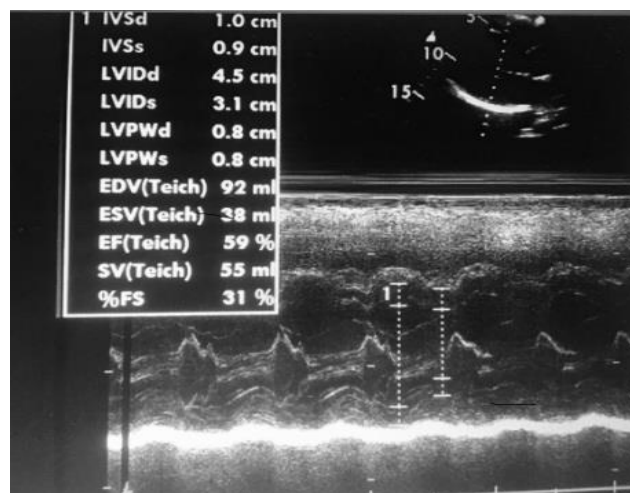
In transthoracic echocardiogram, EF was 59%
